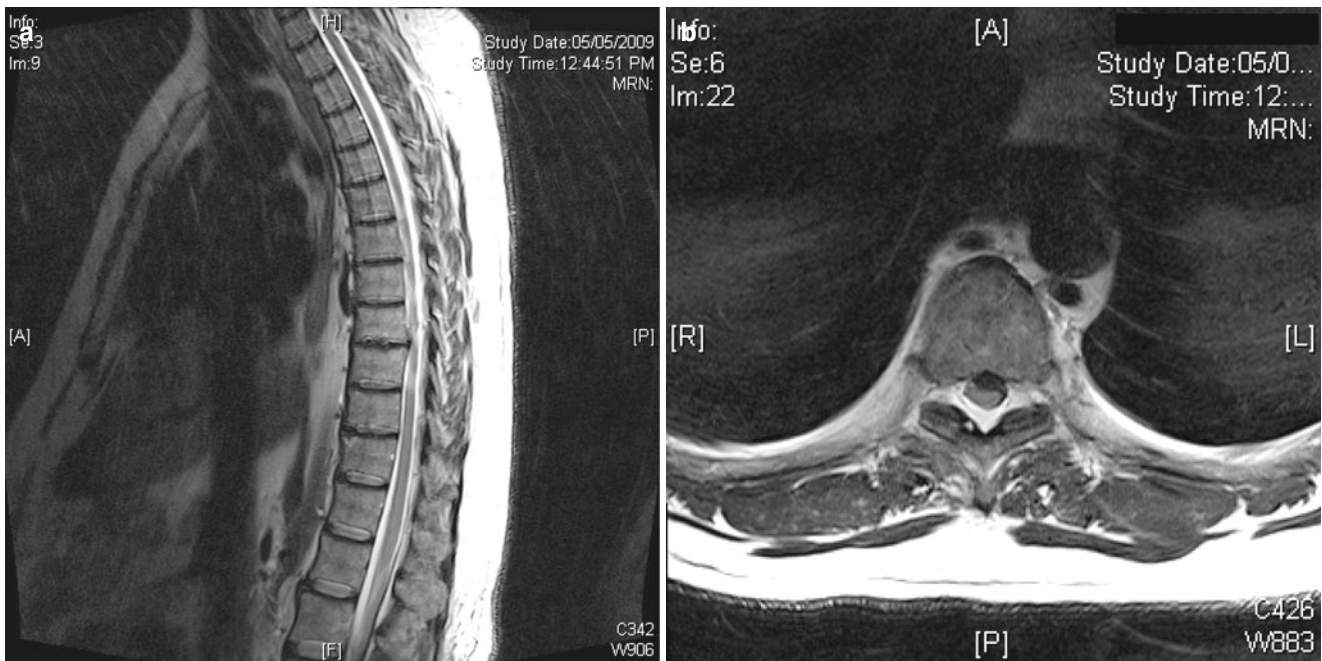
Thoracic herniated disc on MRI. (a) A T8–9 herniated disc on sagittal MRI. (b) Axial MRI showing a left-sided paracentral disc at T8–9 deforming the spinal cord without significant cord signal abnormality
